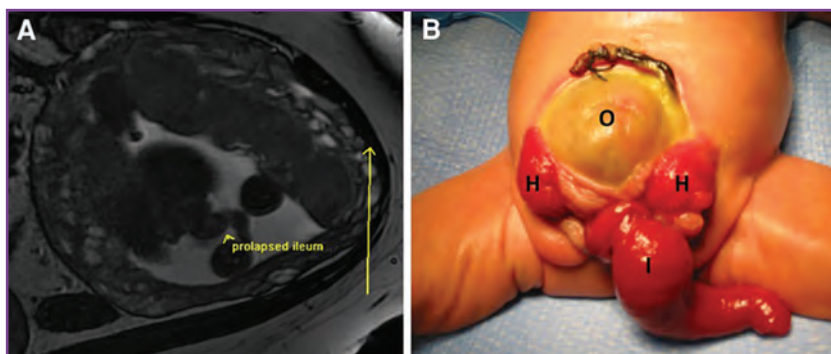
Prenatal magnetic resonance image (A) and postnatal photograph (B) in a patient with cloacal exstrophy, showing the “elephant trunk” sign that represents the intussuscepted ileum. The bladder plate is divided into hemibladders (H) by the omphalocele (O) with an “elephant trunk” ileum (I).
